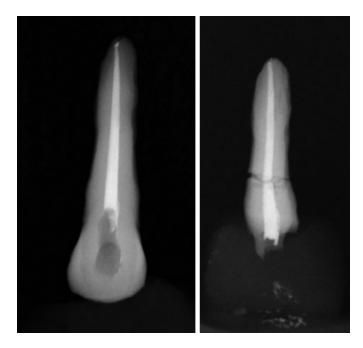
Pre-incineration radiograph of AH Plus sealer (left). Postincineration radiograph of AH Plus sealer (right).
